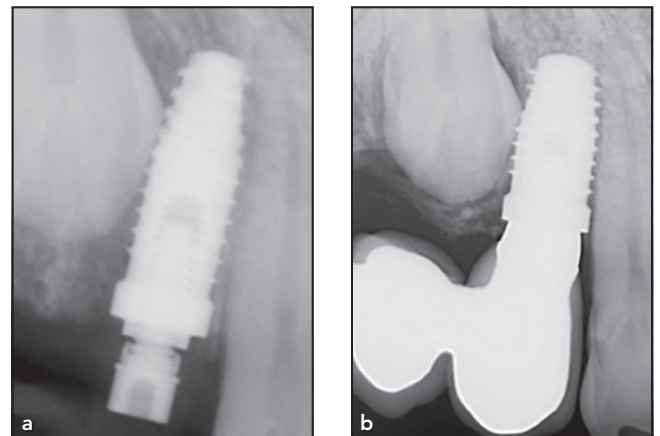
Case 4. Periapical radiographs taken at (a) baseline and (b) the 5-year follow-up.
